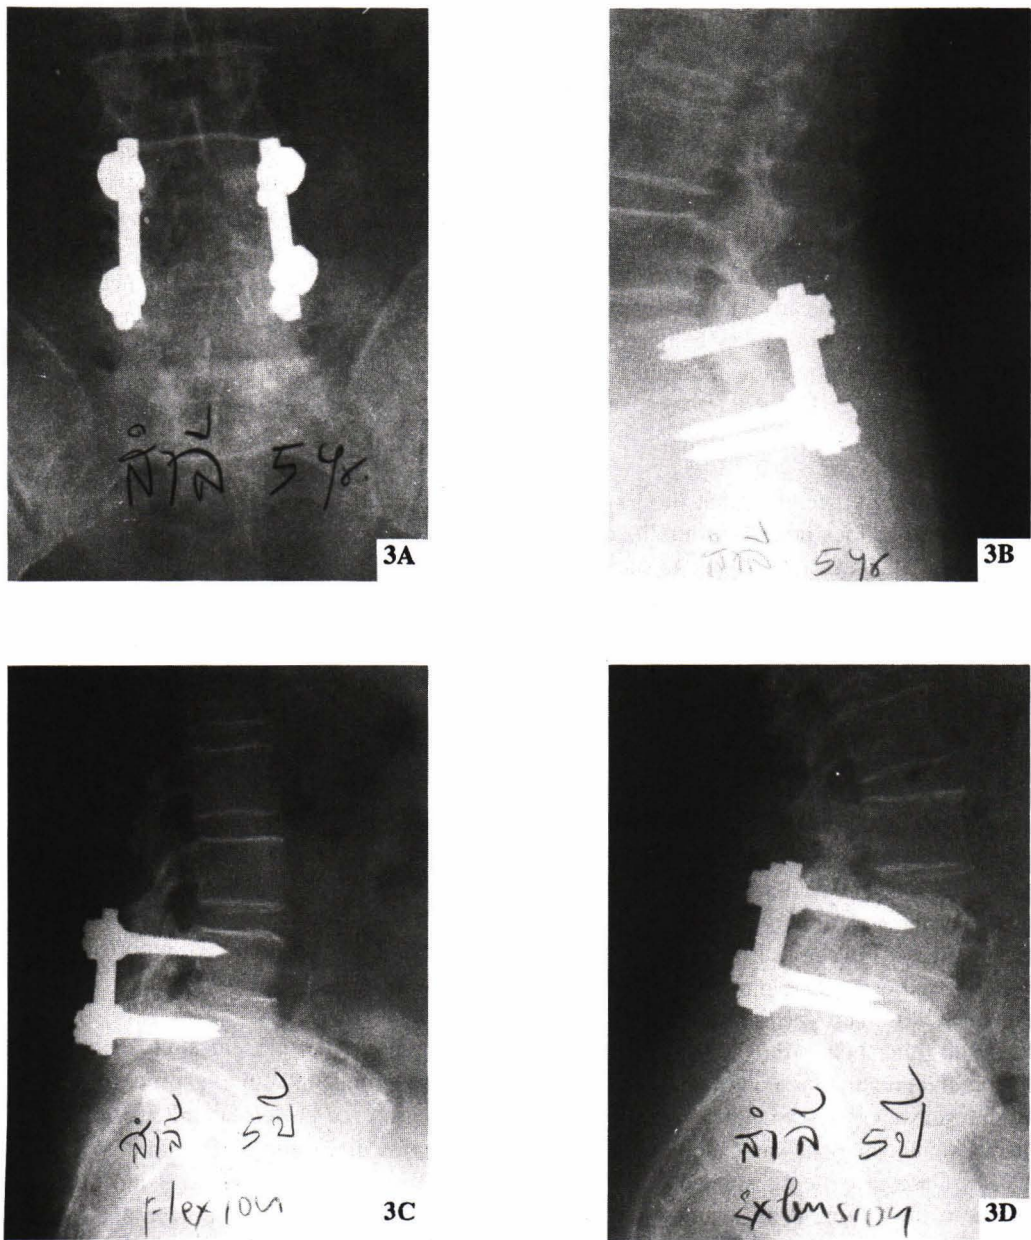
(A-D). The 5th year follow-up X-ray pictures of 52 years old woman, who was performed decompressive laminectomy and PL fusion with laminospinous process bone graft.
